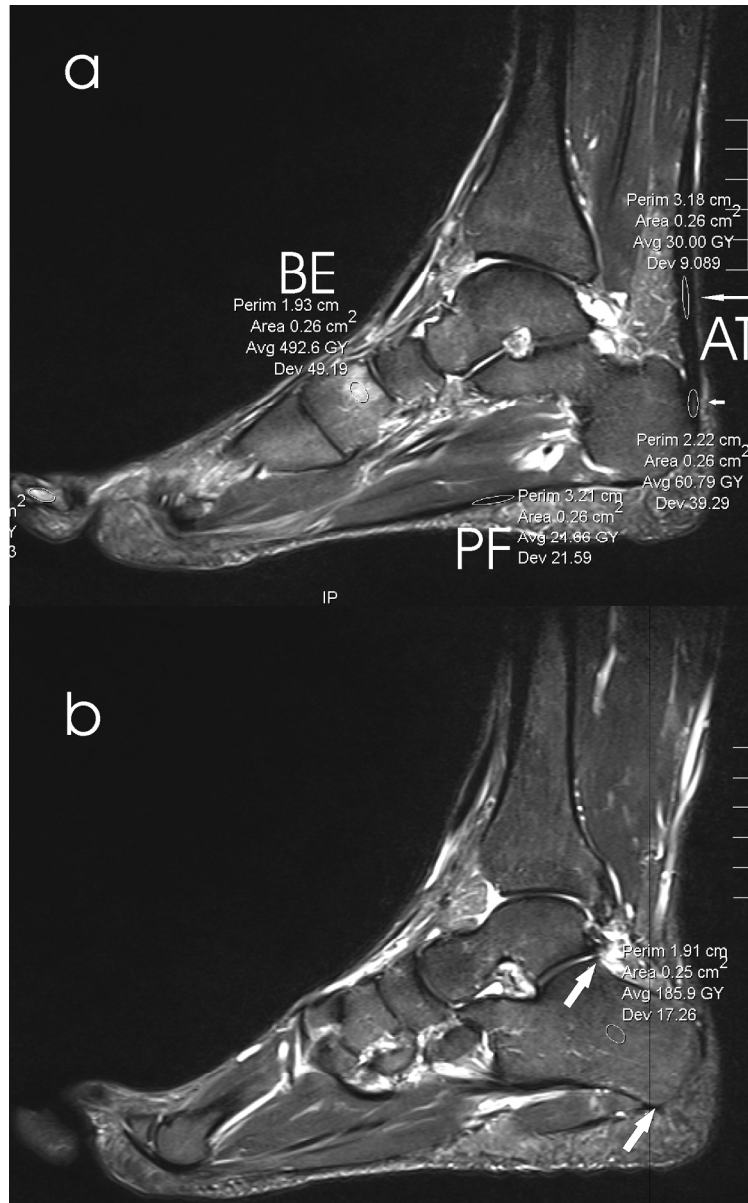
Measurements of MRI parameters on a sagittal STIR weighted MRI scan.
